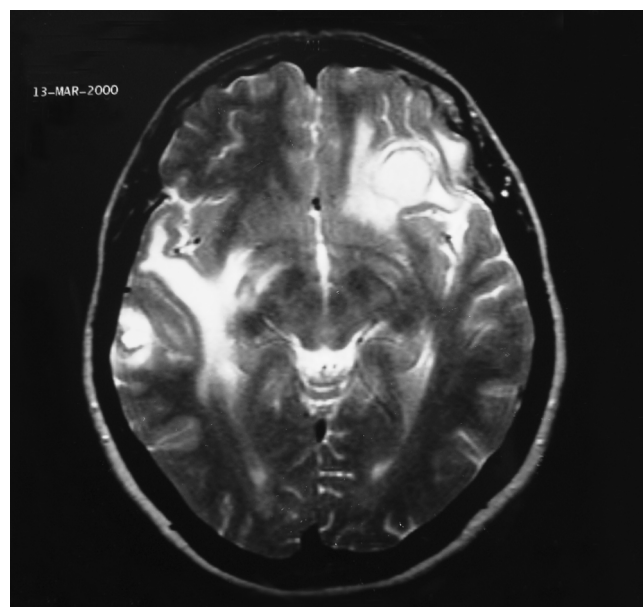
Axial magnetic resonance imaging after gadolinium administration showing irregular enhancing mass in both cerebral hemispheres (2000).
